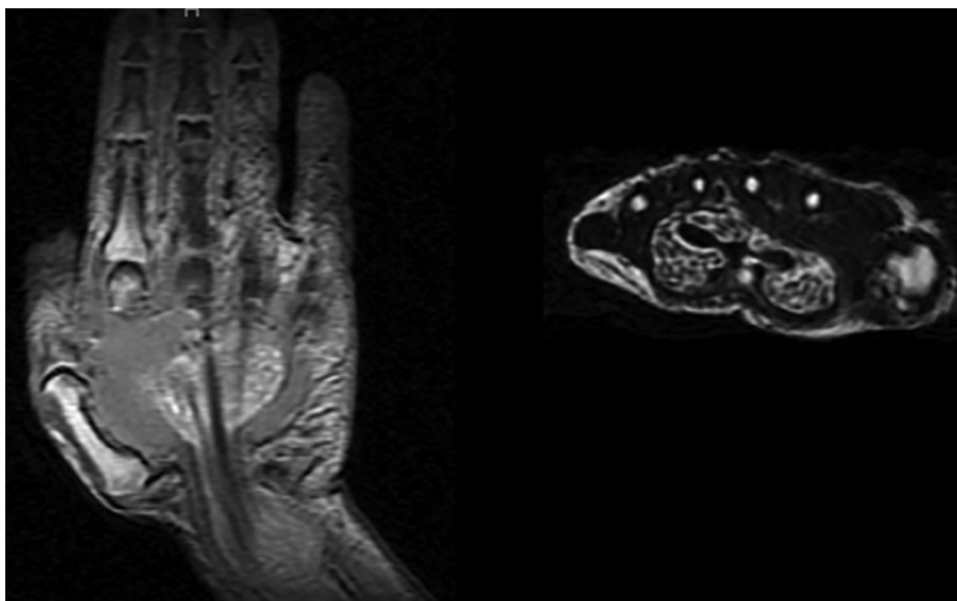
Coronal and axial views of magnetic resonance images showing thickening of the finger flexor sheath on both sides of the carpal tunnel.
